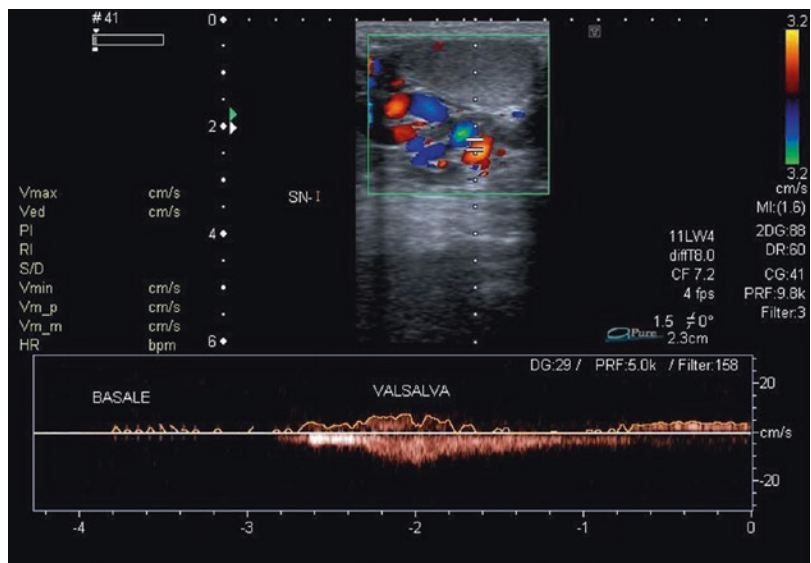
Sarteschi's grade 3 varicocele. Color Doppler images with spectral analysis obtained at rest and during Valsalva maneuver showing dilated veins to the inferior pole of the testis with reflux during Valsalva
